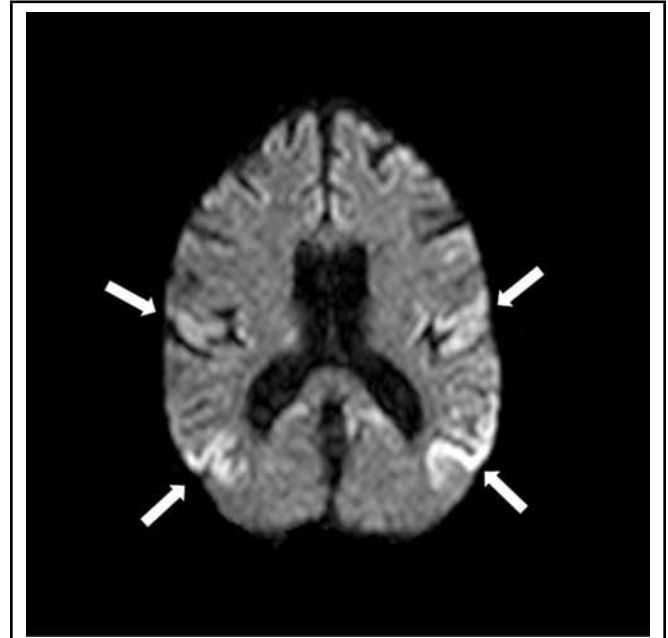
MRI diffusion-weighted images showing restricted cortical diffusion in the bilateral parietal and posterior temporal lobes.
